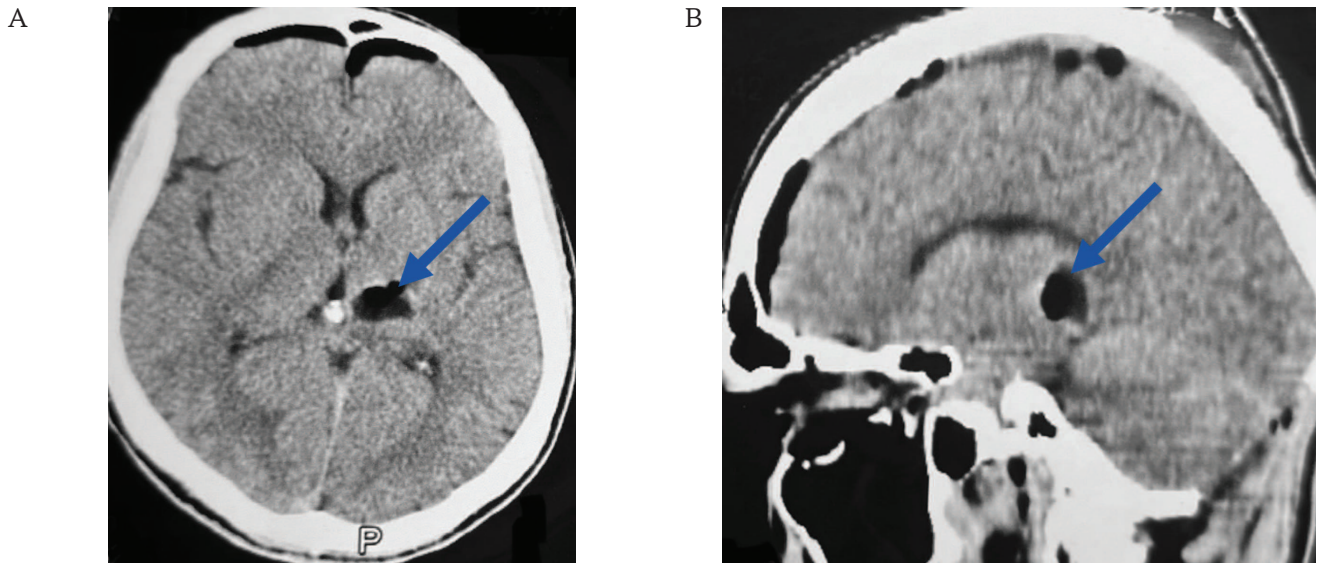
Computed tomography of a 38-year-old patient on the 4th day after removal of a cavernous malformation in the dorsal part of the left peduncle of the midbrain (June 01, 2024).
